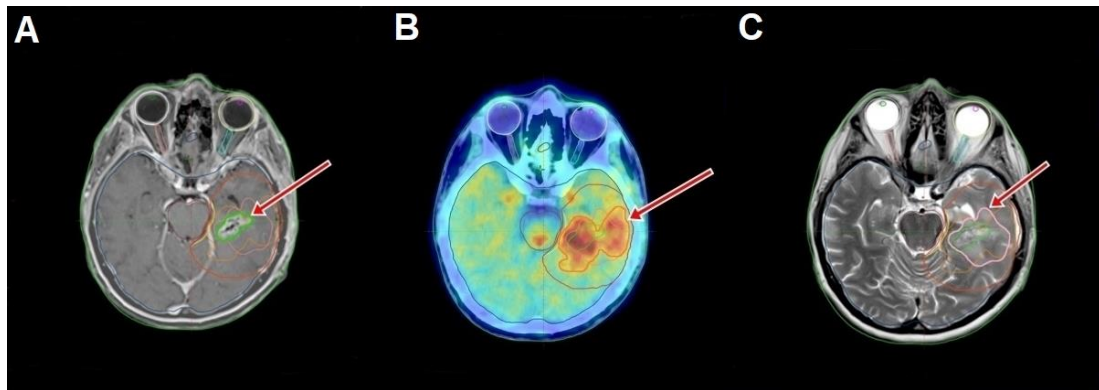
T1-weighted image (A), 18F-FDOPA PET/CT image (B), and T2-weighted image (C). After surgical removal, T2-weighted axial images show an inhomogeneously increased deviation with a signal intensity similar to the previous volume. Edema is observed around the tumor area (A and C image). Medium/high-intensity, multi-focal, sometimes spherical, confluent F-DOPA accumulation is detected, with irregularly shaped, inhomogeneous soft tissue structure with cystic parts in the volume (B image).
